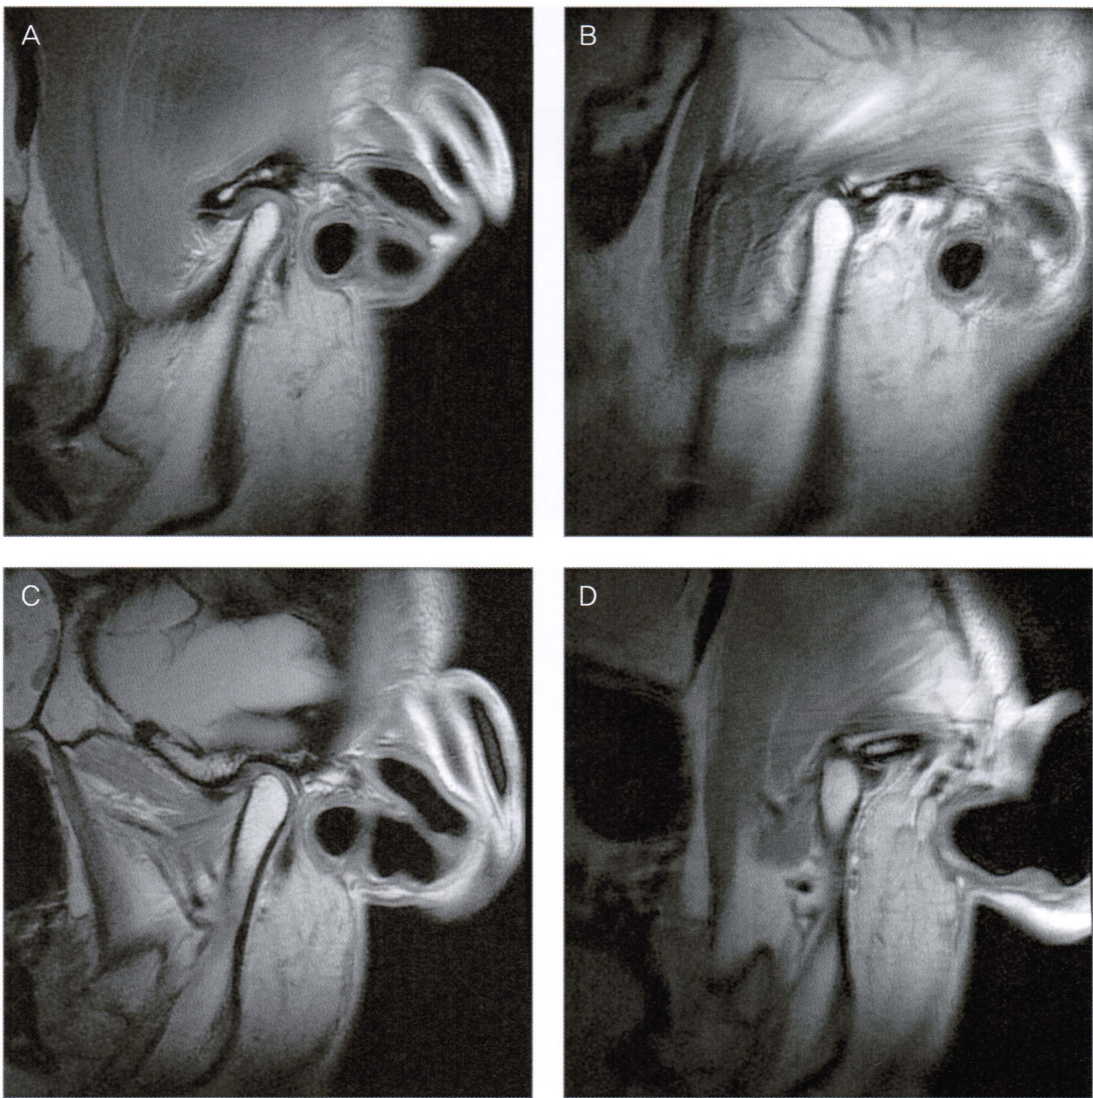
Pre-treatment MRI of the TMJ
